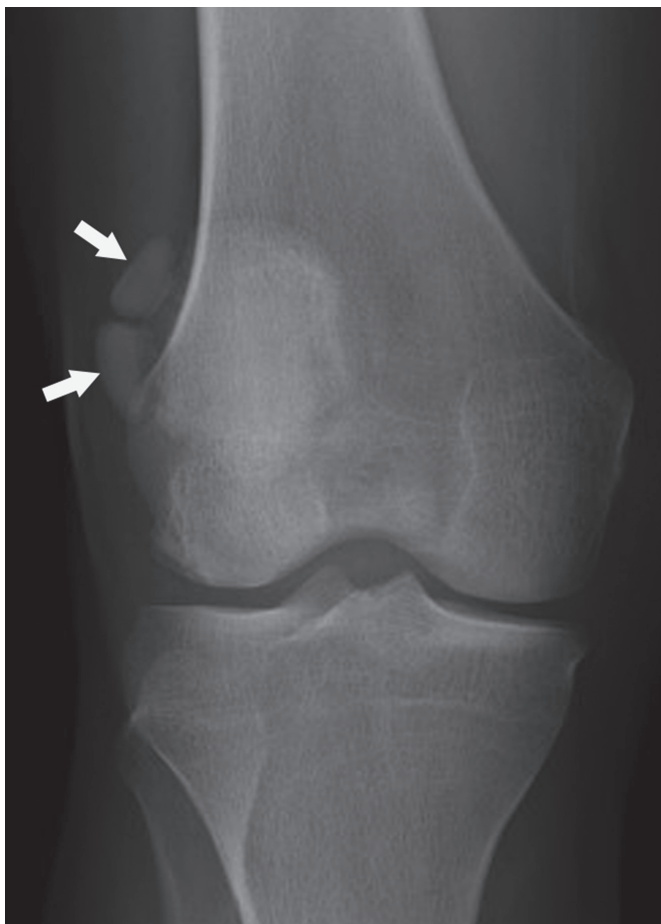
Multi-partite patella. AP radiograph shows two well-defined, non-united ossified secondary ossification centers at the superolateral pole of the patella, consistent with a tri-partite patella.
